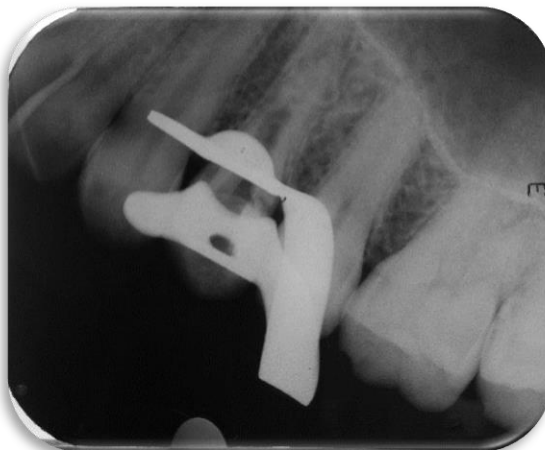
Check radiograph after confirming retrieval of instrument fragment
